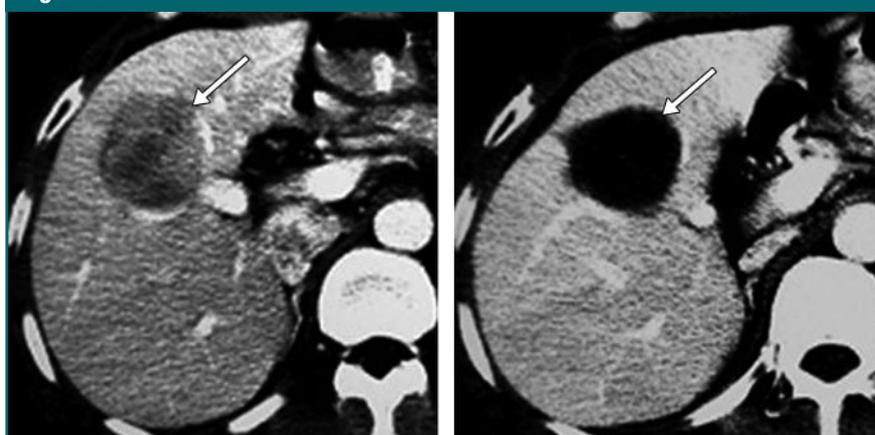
Transverse contrast-enhanced CT scans in 55-year-old female patient who underwent multipronged ethanol ablation of HCC at unfavorable location. (a) Preablation scan (portal venous phase) shows 4.1 \times 4.5-cm tumor (arrow) located above bifurcation of left and right portal veins. (b) Scan obtained 1 month after ethanol ablation (one session, 40 mL of ethanol injected) shows hypoattenuating change of whole target tumor area (arrow).
